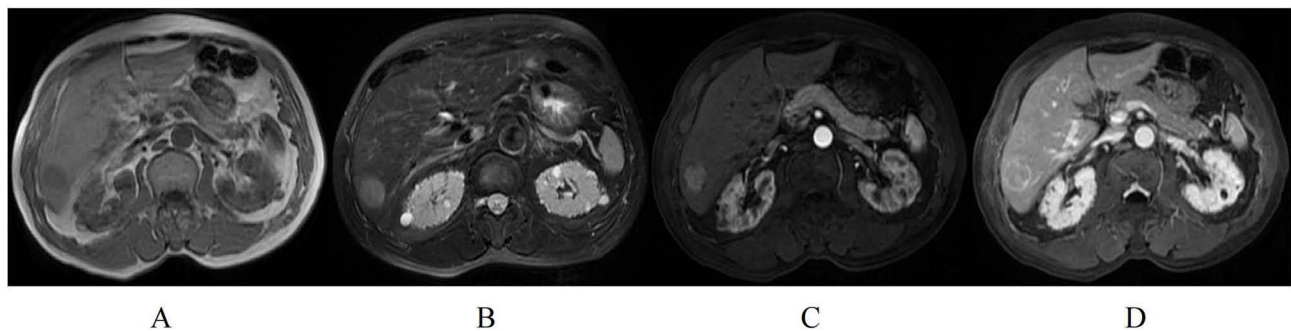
MR images of a 71-year-old male who did not experience postoperative recurrence. (A) Single nodular with homogeneous, slightly low signal on T1WI; (B) The lesion of homogeneous slightly high signal on T2WI; (C) Non-rim arterial phase hyperenhancement (APHE) on the arterial phase; (D) Non-peripheral washout on the portal venous phase.
